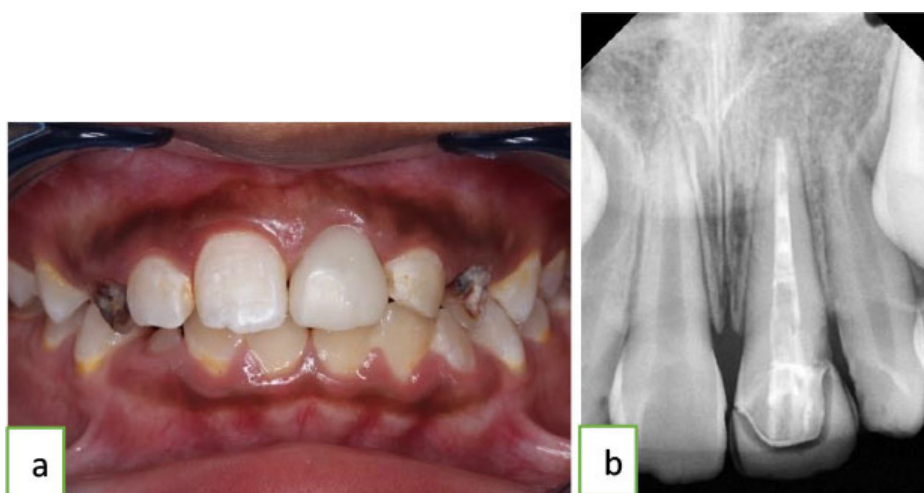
(a) Post operative, (b) Radiograph post operative.
